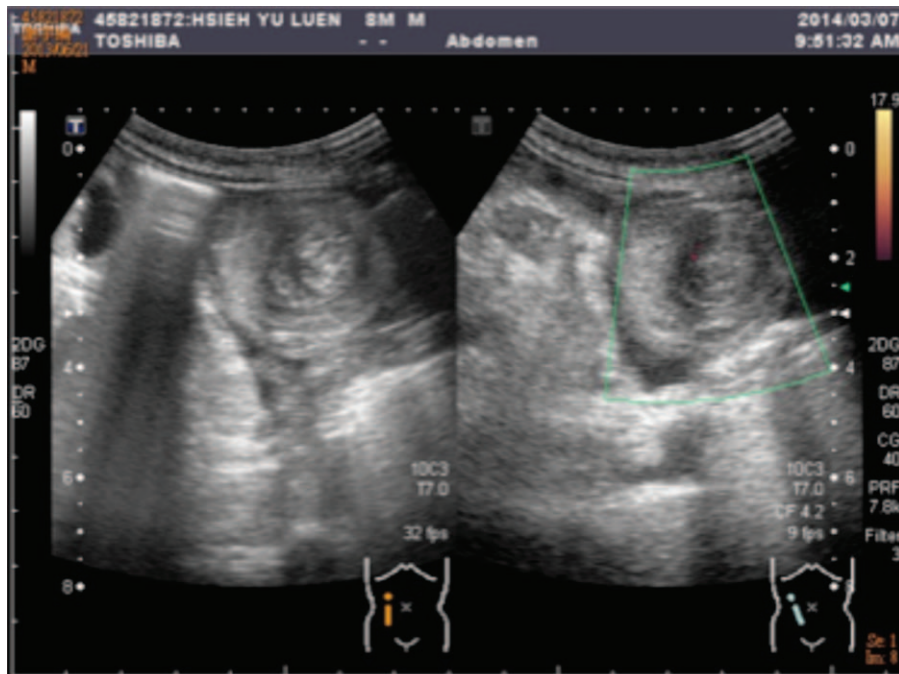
Abdominal sonography: multiple target lesions, indicating intussusceptions.
